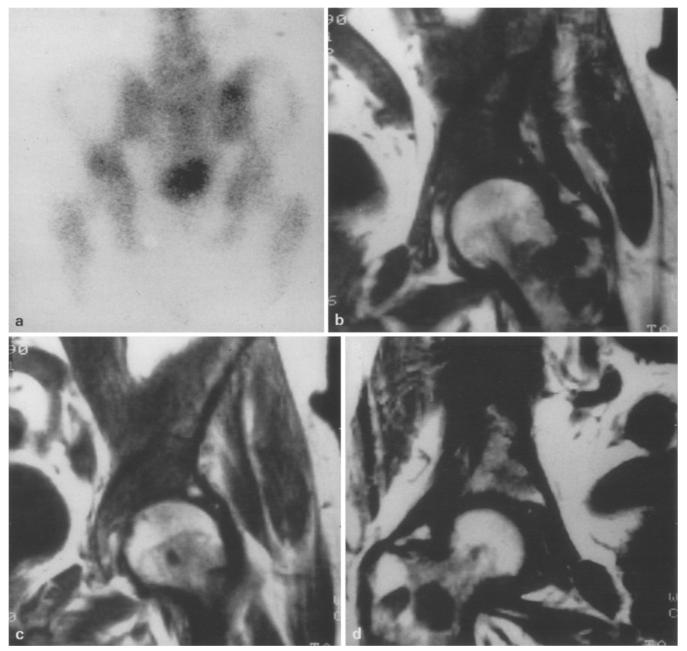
MRI vs BS. a BS centered on pelvis (posterior view) showing metastases of left hip, right part of sacrum and right hip. b, c MRI centered on left hip exhibiting metastasis shown by BS
